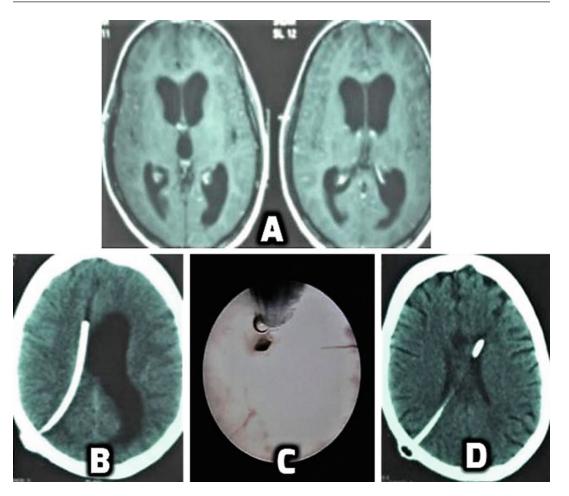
Endoscopy for septostomy in non-communicating hydrocephalus developing in a shunted patient (a) Axial plain MR image showing hydrocephalus (b) Axial plain CT image showing isolated left lateral ventricle due to
